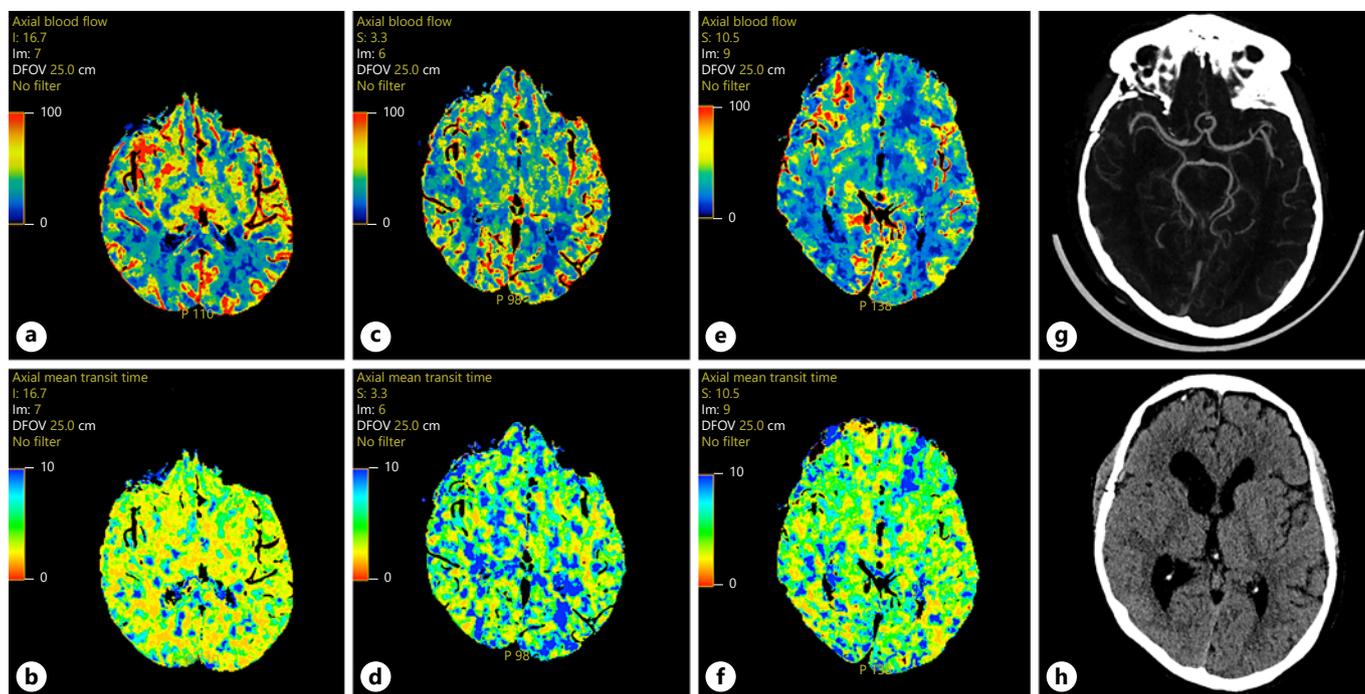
Evolution of brain CT perfusion, CT angiography, and CT at discharge. a, b Blood flow map (CBF) and MTT demonstrate normal symmetric brain perfusion. c, d CBF and MMT demonstrate diffuse hypoperfusion, with mild decreased CBF at the beginning of HP + HVHF. e, f CBF and MMT show mild diffuse hypoperfusion, better than previous CT perfusion after HA-380
